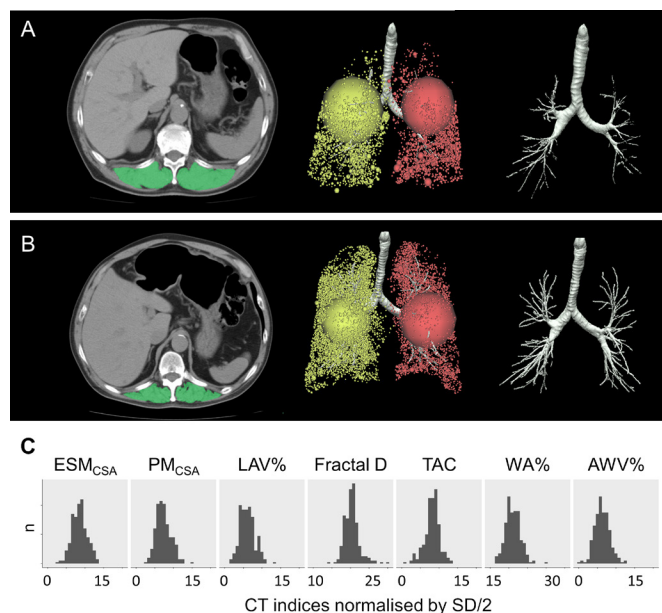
Two COPD cases with different cross-sectional areas of the erector spinae muscles on CT and distributions of normalised CT indices in all 247 cases. (A, B) The ESM_{CSA}, emphysema and airway indices were measured on CT scans in this study. The ESM_{CSA} was larger in case A than in case B (41.9 vs 21.0 cm²). The TAC was also smaller in case A than in case B (178 vs 283), whereas the height (160 vs 163 cm), FEV₁ (1.12 vs 1.00 L), mMRC score (both 1) and LAV% (29.2 vs 29.5%) did not differ between the two cases. (C) Histogram of each CT index that was normalised by half of a SD. The distribution patterns, represented by the shape and range of histograms, were similar for all the normalised indices. This allowed a comparison of the relative impacts that are associated with a 1-normalised unit change. AWW%, airway to lung volume ratio; ESM_{CSA}, cross-sectional area of erector spinae muscles; fractal D, fractal dimension of low attenuation clusters; LAV%, low attenuation volume percentage; mMRC, modified Medical Research Council; PM_{CSA}, cross-sectional area of pectoralis muscles; TAC, total airway count; WA%, wall area percentage.
